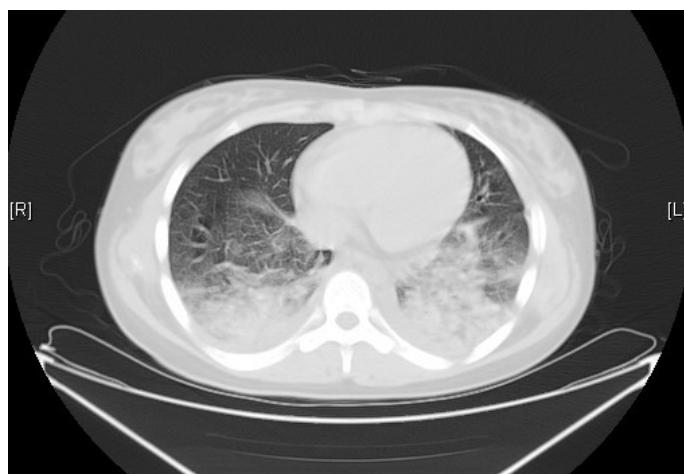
Computed Tomography of the Chest in acute stage
